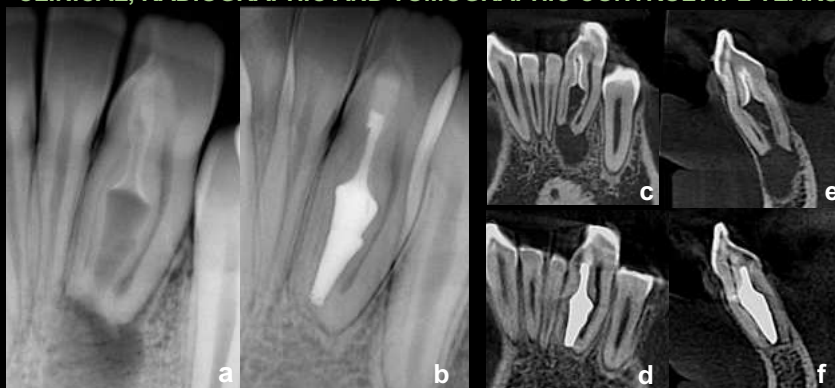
(a), Initial X-ray. (b), Control x-ray at 2 years. (c), Initial coronal section. (d), Coronal section at 2 years. (e), Initial sagittal section. (f), Sagittal section at 2 years. Complete bone healing and apical closure are observed.
